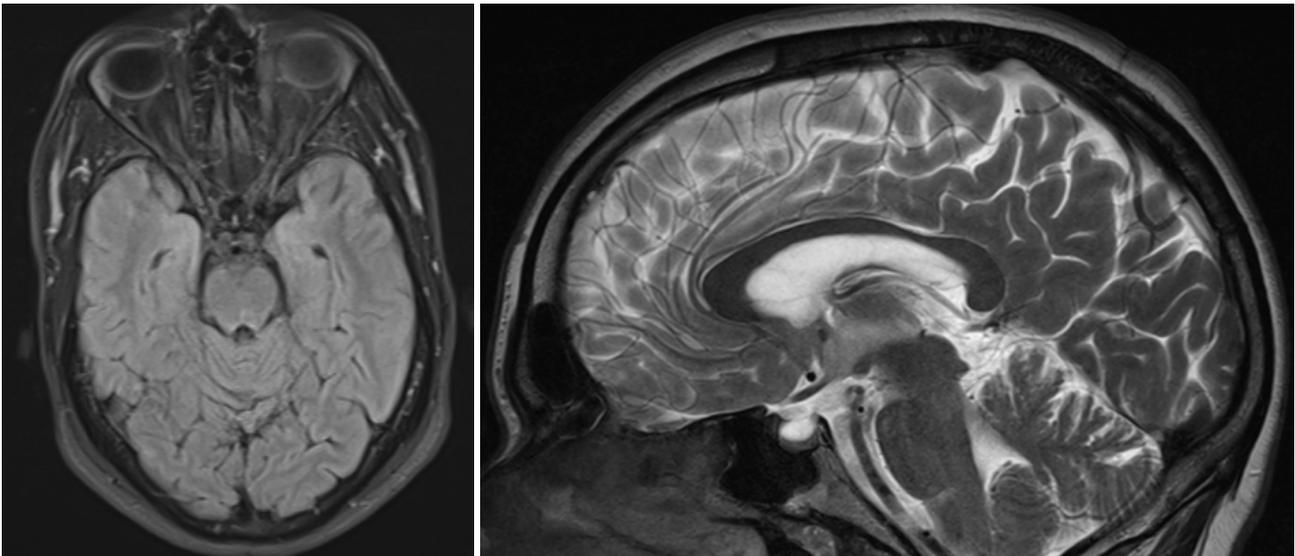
Follow-up brain magnetic resonance imaging, 6 months after rituximab therapy, showing total resolution of the pachymeningeal thickening
